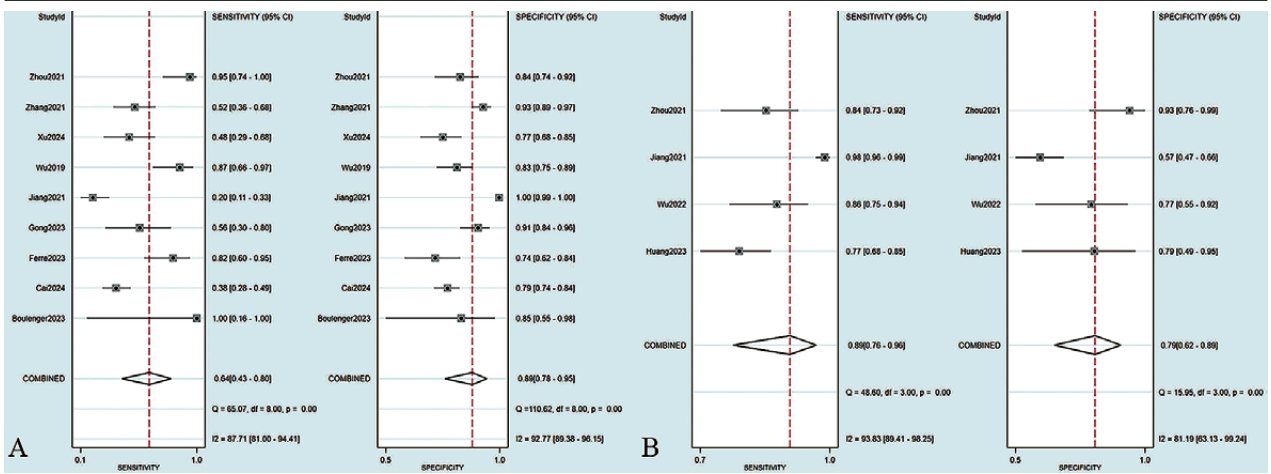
Forest plots of the sensitivity and specificity of ultrasound radiomics in predicting (A) TNBC and (B) Luminal breast cancer
